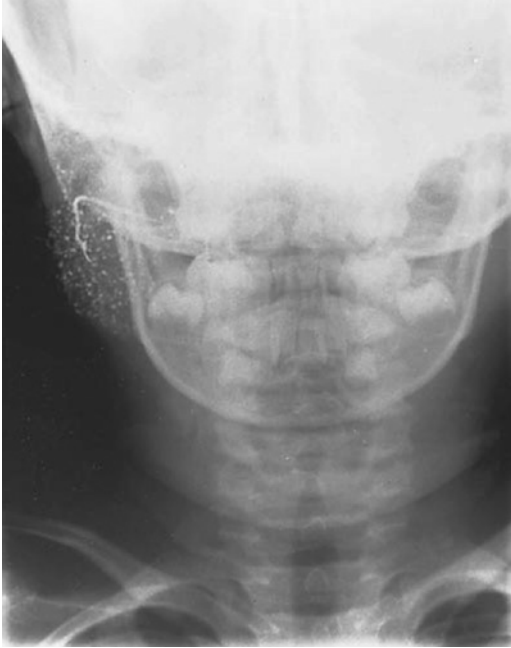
Sialogram showing sialectasis. A contrast x-ray of the parotid duct showing a *snowstorm* of saccular dilatations of the lesser ducts in the enlarged parotid.
